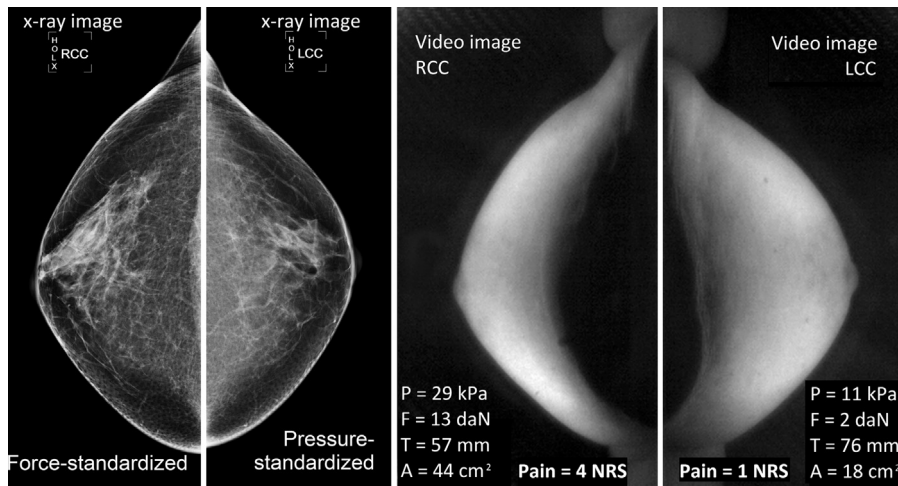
Example of under-compression: left panels: X-ray images with exceptional contrast difference in the pressure-standardized compression (LCC). Right panels: corresponding visual images of the compressed breast (from video-camera positioned above the compression paddle). The contact area (shadow area on the breast) is much smaller in the pressure-standardized compression (rightmost panel).
